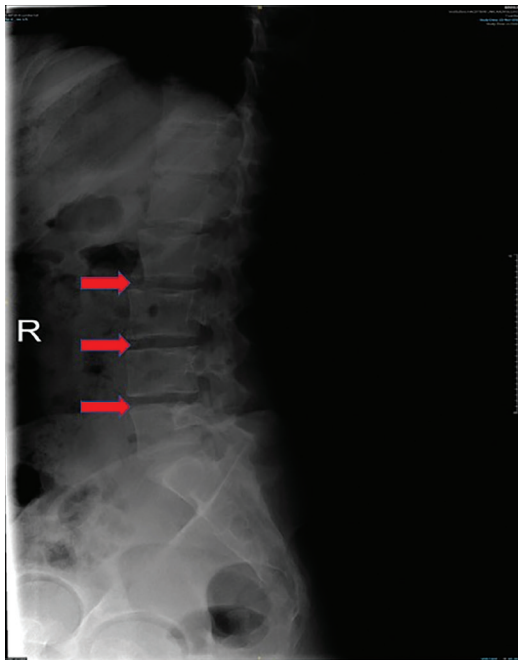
Lateral conventional lumbosacral radiograph. Twenty-four-year-old female patient. Complaints of back pain that increases with movement. CRP: 0.3 mg/dL. Spondylodiscitis caused by spondyloarthritis. Lumbar MRI: There are erosive changes compatible with Anderson lesions in the end plates adjacent to the L2-3, L3-4 and L4-5 discs. There is no abscess. Culture was not taken. Eleven of 11 rheumatologists (100%) could not recognize spondylodiscitis on conventional radiography
